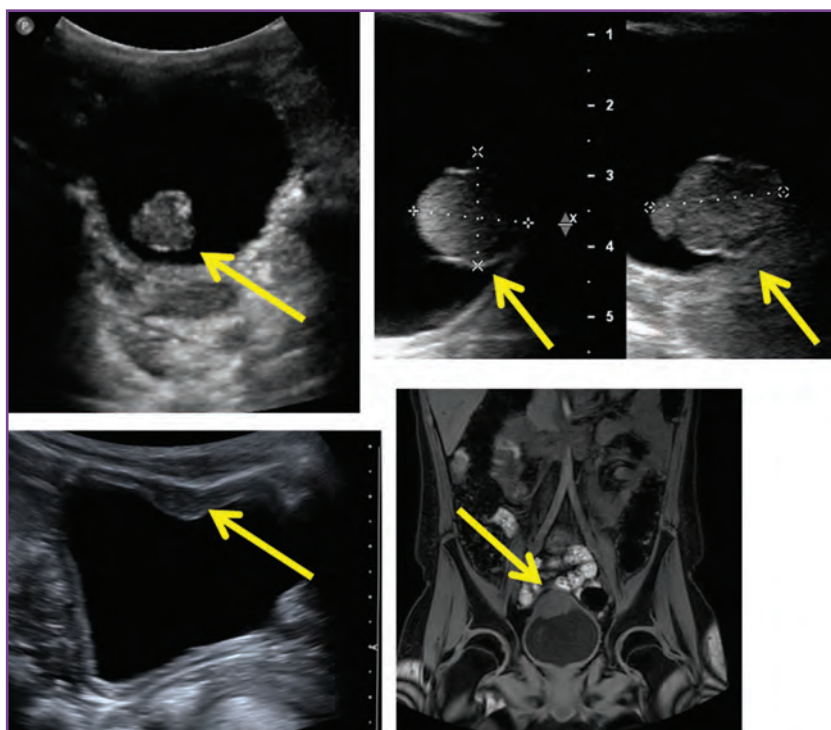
Various bladder masses (arrows) as depicted with ultrasonography (A, B, C) and coronal magnetic resonance imaging (D).
